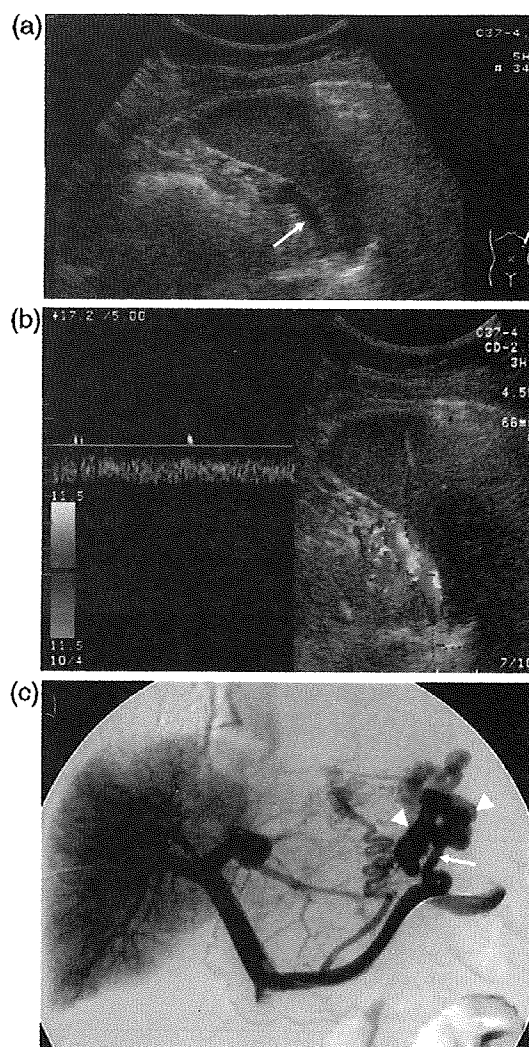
59-year-old female, cirrhotic patient with FV. (a) B-mode US by left intercostal scan. The short gastric vein (SGV, arrow) was demonstrated beside the spleen by left intercostal scan. (b) Pulsed and color Doppler US by left intercostal scan. Flow direction of SGV was hepatofugal. (c) Portogram. SGV (arrow) was observed running toward the FV (arrow heads), FV, gastric fundal varices.
